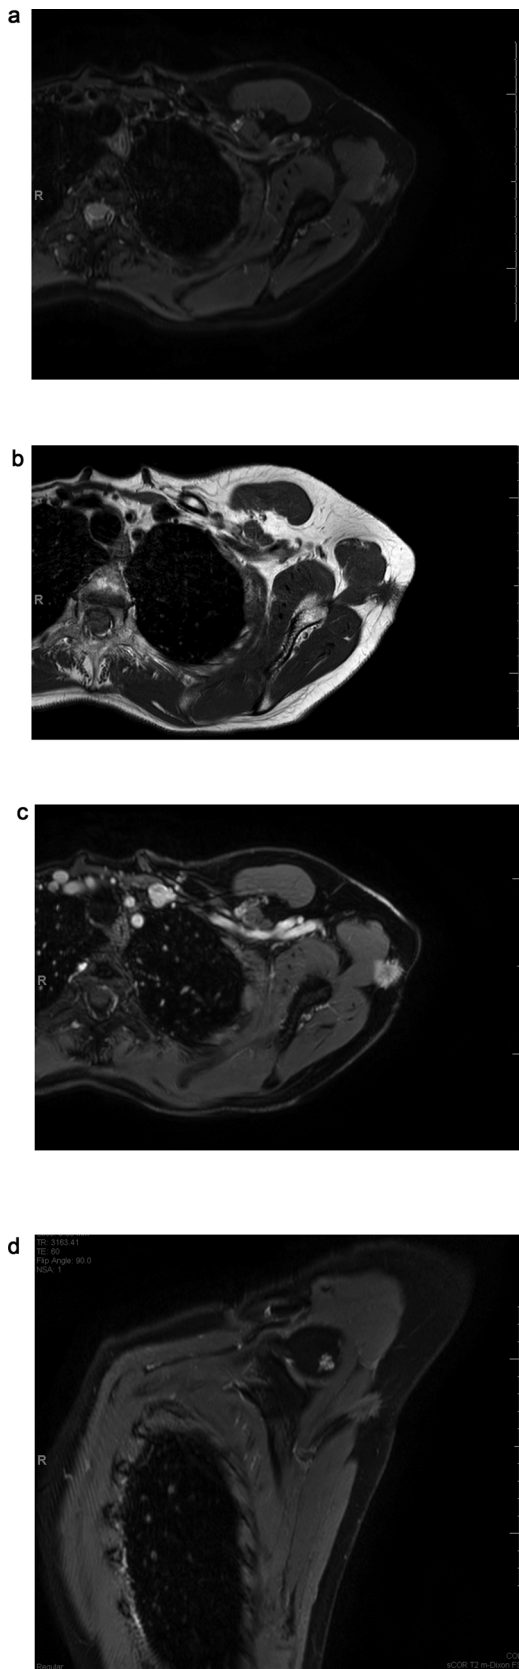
2a. thoracic MRI Showing a 18 mm speckled contrast enhancing lesion (arrow) fixed to the superficial skin and deep muscle layers. 2b. enlarged axial image of the lesion in T1 before gadolinium; 2c. after gadolinium; 2d. T2 coronal image.
